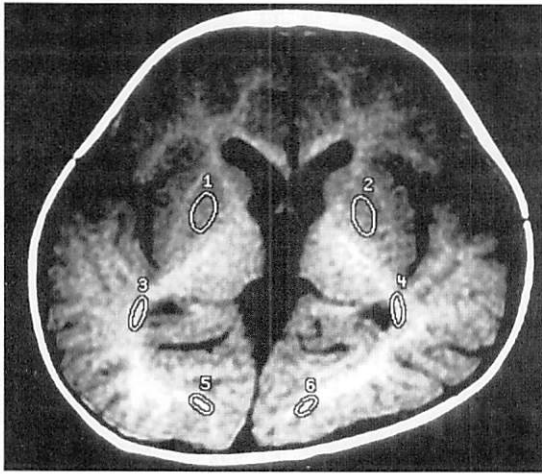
Examples of selected regions of interest for assessment of myelination on T1-weighted images (repetition time 350/echo time 20): bilateral putamen (1 and 2), proximal optic radiation (3 and 4), and distal optic radiation (5 and 6).
